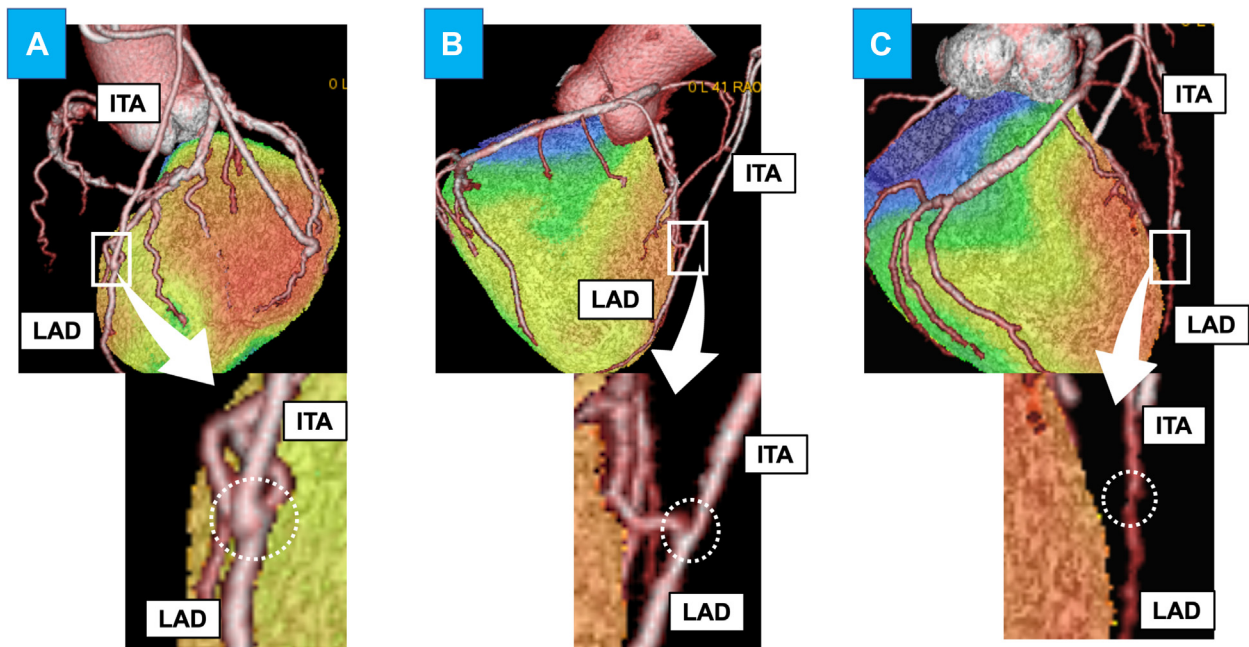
Representative 3-dimensional rendering images of coronary computed tomography scan assessing percent stenosis of coronary arterial anastomosis. Independent radiologists blinded to transit-time flow measurement data reviewed the images and categorized each anastomosis into three patency grades. A, Successful (no or $\leq 50\%$ stenosis), anastomosis of the left internal thoracic artery (ITA) to the left anterior descending artery (LAD) showing an ideal external shape with adequate bulge. B, Subcritical (50%-74% stenosis), anastomosis of ITA to the LAD showing mild stenosis just proximal to the anastomosis site. C, Critical ($\geq 75\%$ stenosis), anastomosis of ITA to the LAD showing highly stenosed anastomosis with low contrast enhancement of the LAD.
